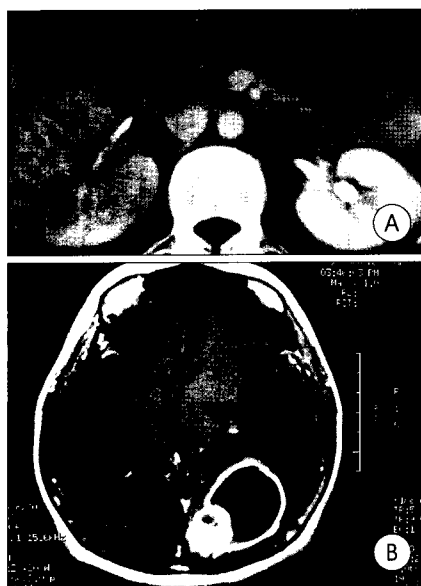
A : An abdomen computed tomography shows a marked enlarged right kidney with multilobulated septation and destructed normal calyx pattern. B : The brain magnetic resonance image with enhancement shows a well enhancing cystic tumor mass having a irregularly thickened wall on left occipital lobe.
